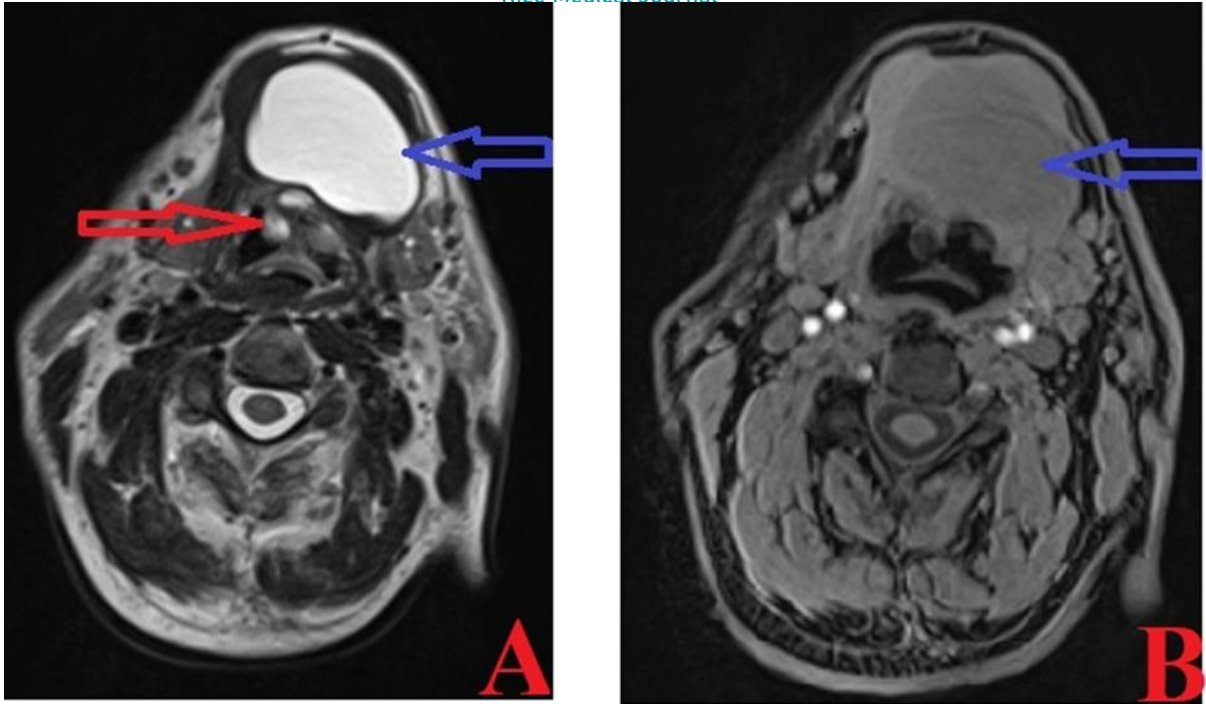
Magnetic resonance imaging (MRI) shows a cystic mass (blue arrow) and valvular cysts (A) (red arrow) in T2 (A) and T1 (B) axial plane.
